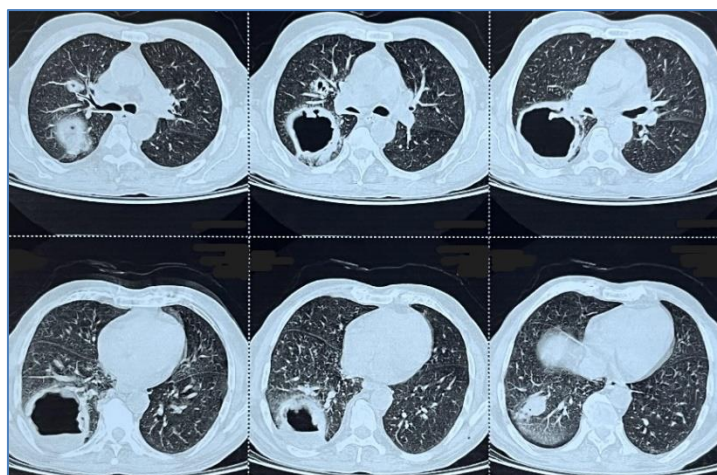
HRCT thorax showing large thick-walled cavity in superior segment of lower lobe with accompanying 'sister cavity' in posterior segment of upper lobe
